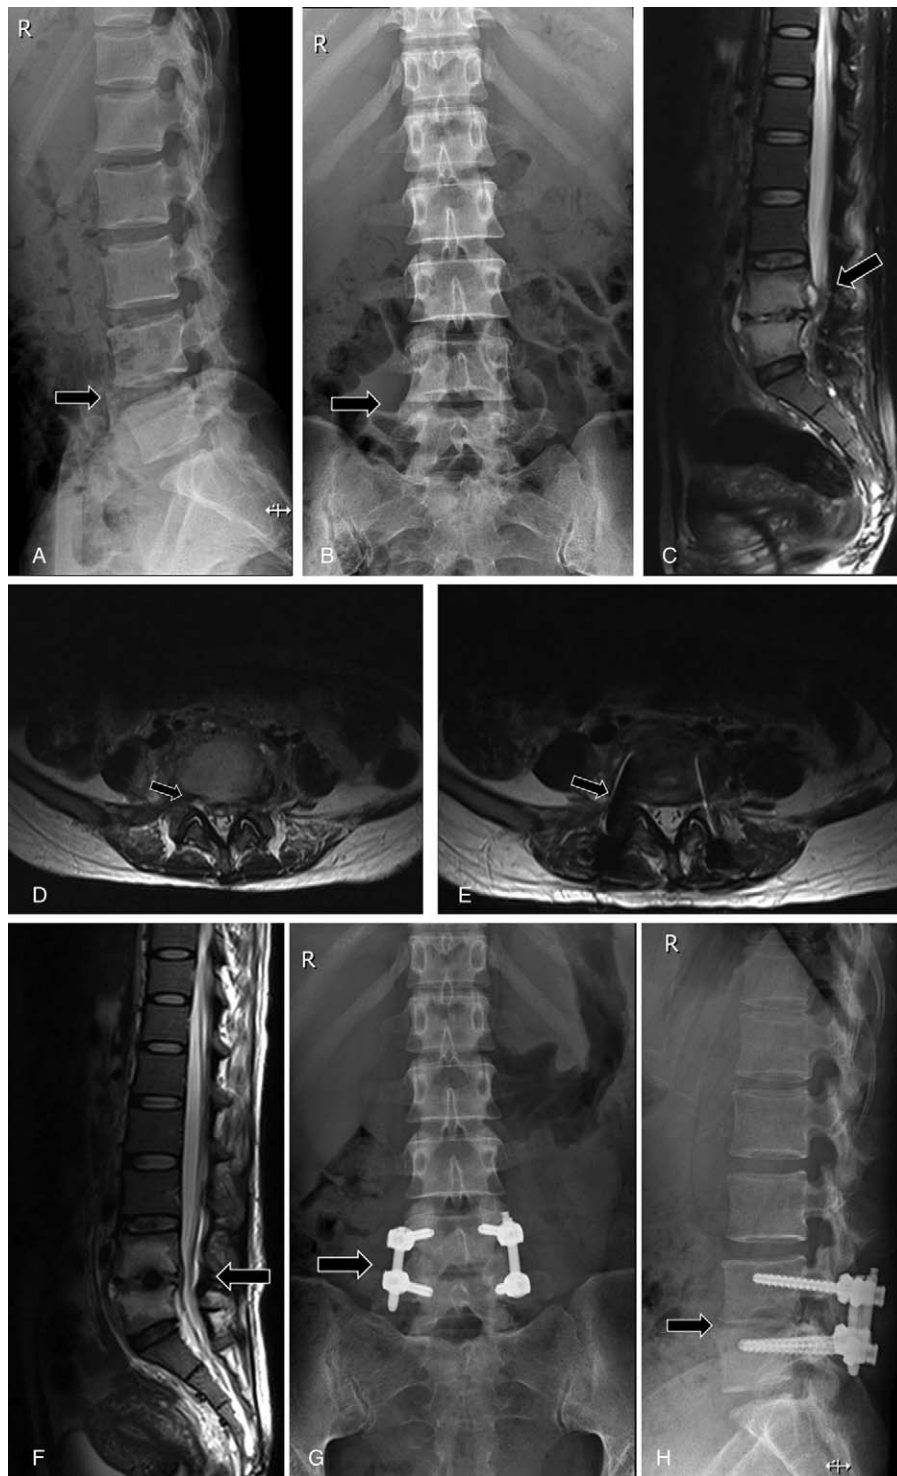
(A and B) Anteroposterior and lateral plain radiograph revealed osteoarthritic changes of the lumbar spine. There is a loss of lordosis on the lumbar spine by narrowing of the intervertebral disk space between the L4 and L5. (C and D) Magnetic resonance imaging (MRI) of the lumbar spine demonstrated spondylitis of the fourth and the fifth lumbar vertebrae, as well as destruction of intervertebral disk between them, where it is associated with paravertebral and epidural components with compression of the spinal cord. Swelling soft tissues paravertebral were also observed. (E and F) Postoperative magnetic resonance imaging (MRI) showed that abscess was drained and adjacent inflammatory tissues were removed, as well as swelling subsided. Compression of the spinal cord was relieved. (G and H) Postoperative 4 months, plain radiograph showed segmental instrumentation from L4 to L5 vertebrae. Appearances of edge sclerosis and L4/5 partly fusion were observed.
